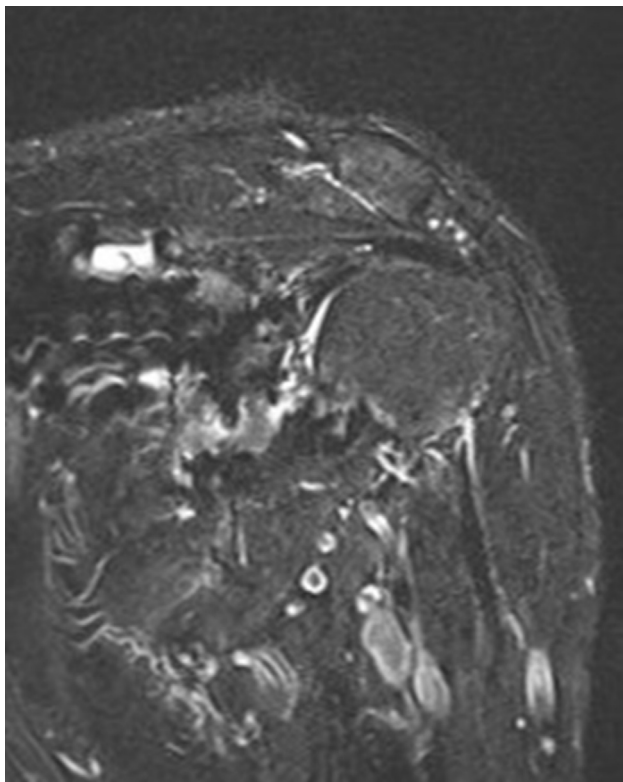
MRI on the first postoperative year showing slightly increased T2-STIR signal intensity of the infraspinatus. MRI, magnetic resonance imaging; T2-STIR, T2-weighted short tau inversion recovery.
